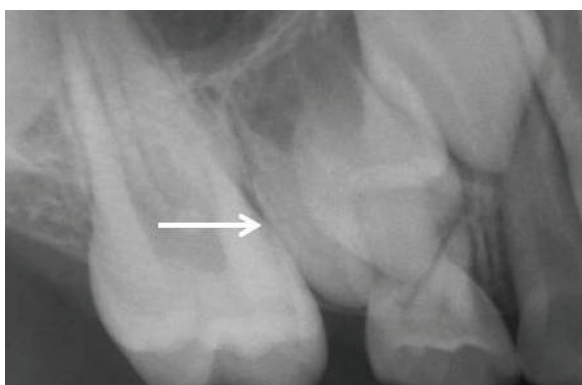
Intra-oral periapical radiograph showing conical shaped supernumerary tooth in premolar region
